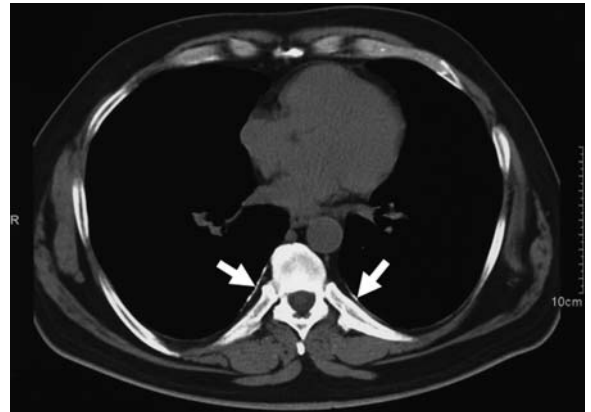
Computed tomography scan of the chest shows posterior calcified pleural plaque appearing as a discrete smooth line of calcium attenuation (*arrows*)
